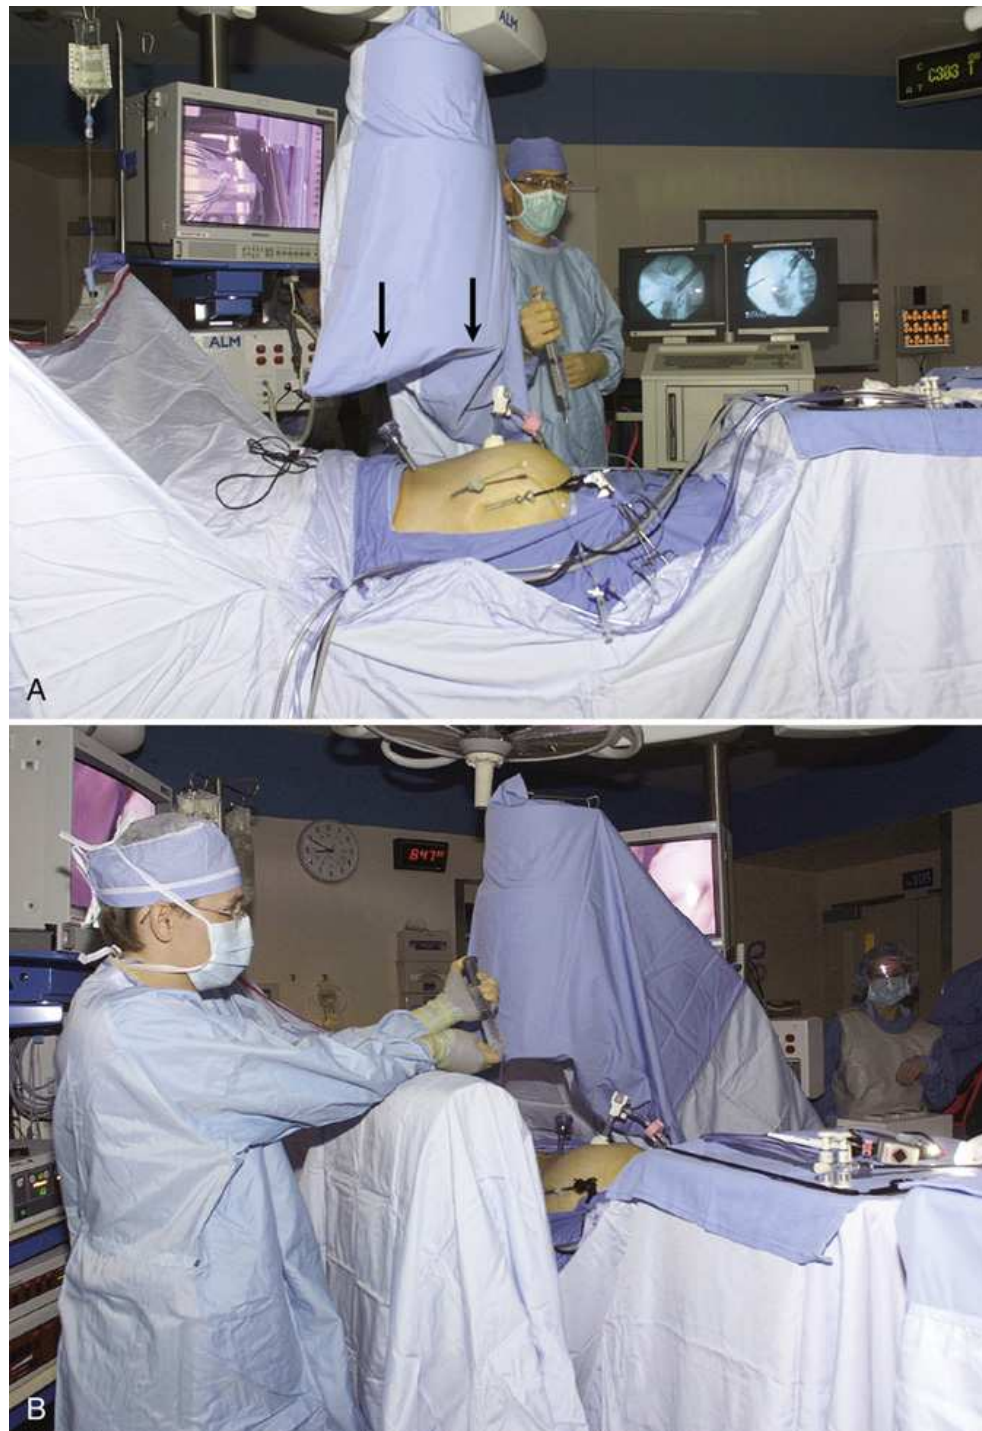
(A) C-arm in correct position for an abdominal cholangiogram. The assistant surgeon checks syringe for air bubbles before handing it to the surgeon for injection. The radiographer positioned fluoroscopic image intensifier (*arrows*) carefully to avoid hitting laparoscopic instruments protruding from the patient's abdomen. (B) Surgeon, standing behind a sterile draped lead shield, injecting contrast media for an operative cholangiogram.
